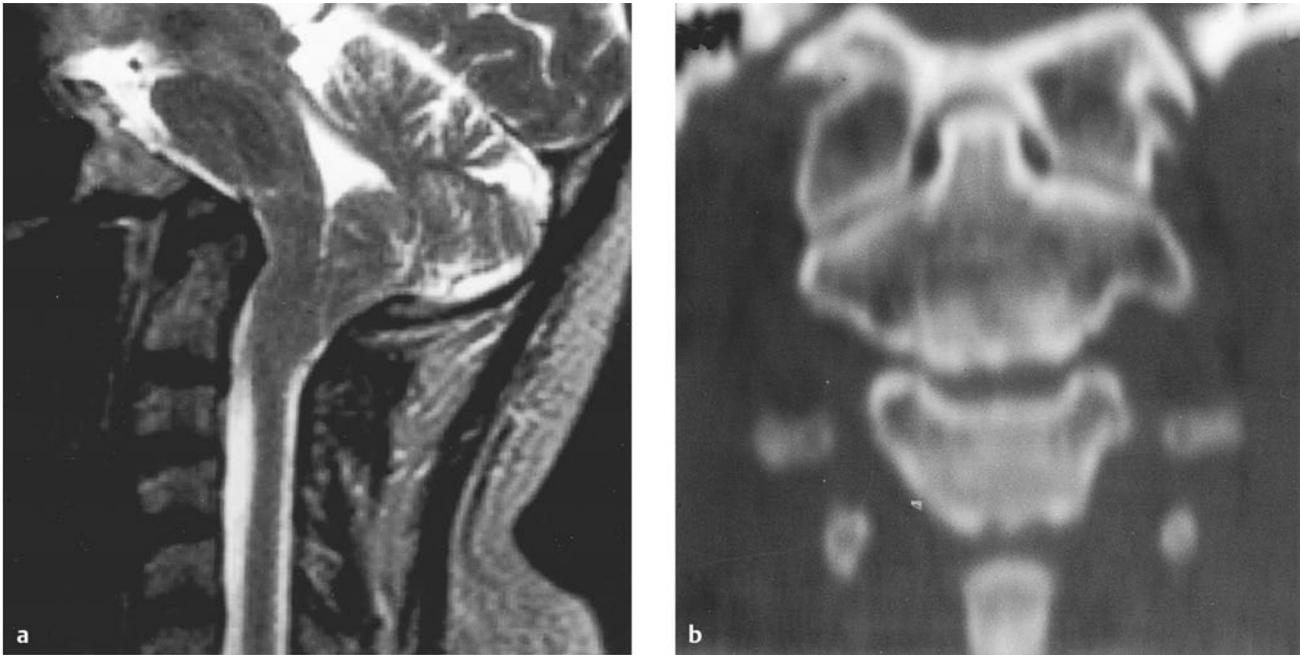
(a) Midsagittal T2-weighted magnetic resonance imaging of the craniocervical region. This demonstrates a hypoplastic basiocciput, with the clivus nearly horizontal. There is atlas assimilation, with the anterior arch of the atlas located between the inferior clivus and the odontoid process. The vertical height of the posterior fossa is grossly reduced. The clivus-odontoid articulation indents into the mid medulla. Hindbrain herniation is visualized. (b) Coronal computed tomography through the plane of the odontoid process reveals atlas assimilation and abnormal craniocervical relationships.
